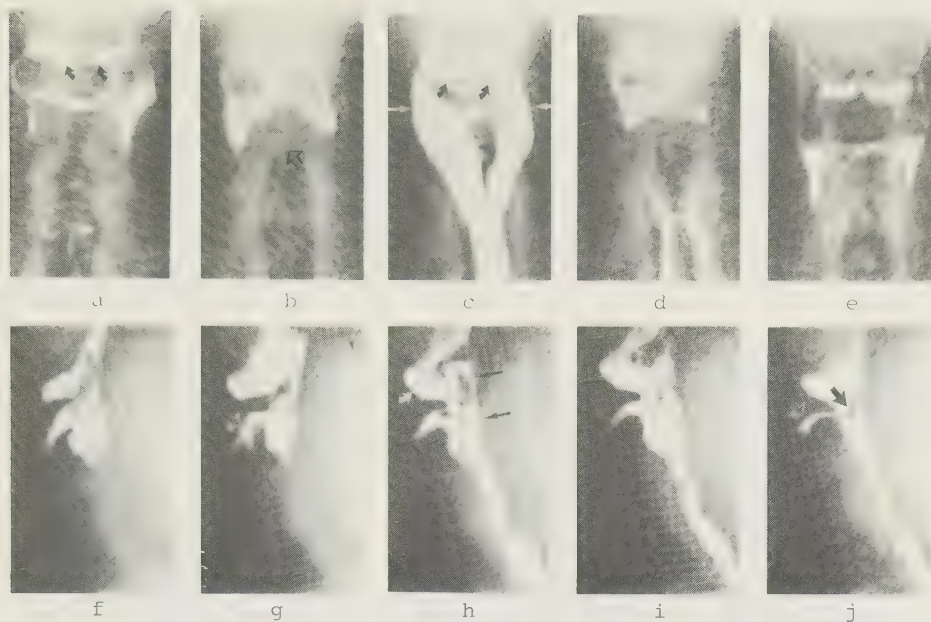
a-e AP view, f-j lateral view. Sequence from a cine-radiographic examination. The valleculae (bent arrows) are not effaced in the AP view due to the immobility of the epiglottis. The epiglottis attains a somewhat accentuated upward concavity (thick arrow) but does not tilt down. No contraction is observed in the pharyngeal constrictor musculature (thin arrows). Contrast medium has entered into the laryngeal vestibule (open arrow).
